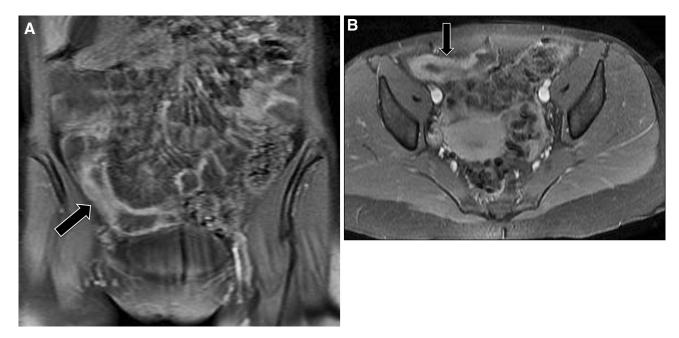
Coronal (A) and axial (B) post-contrast T1 weighted fat-saturated MRI images of the lower abdomen and pelvis show wall thickening and hyperenhancement of the terminal
